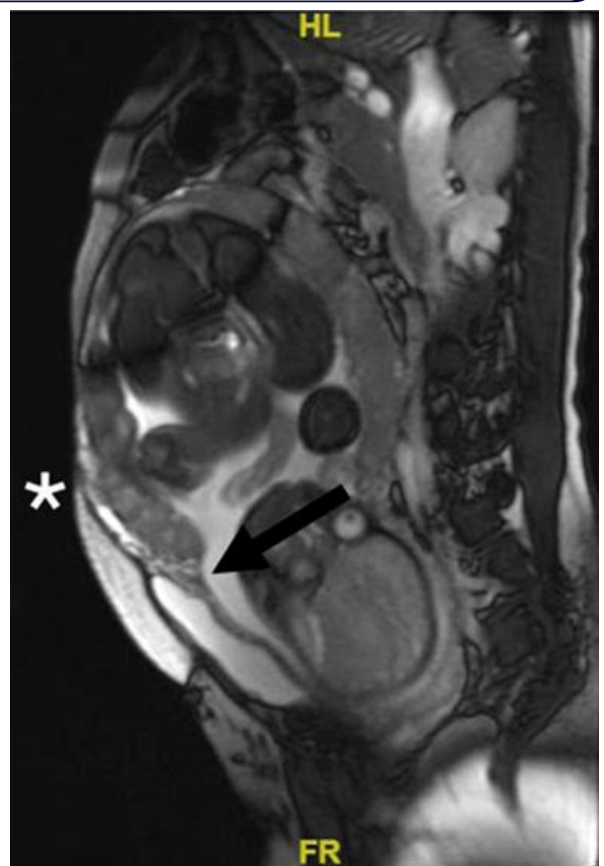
T2 weighted sagittal MRI image showing low lying placenta with focal invasion into posterior bladder wall (black arrow) and thinning of myometrium(asterix)
